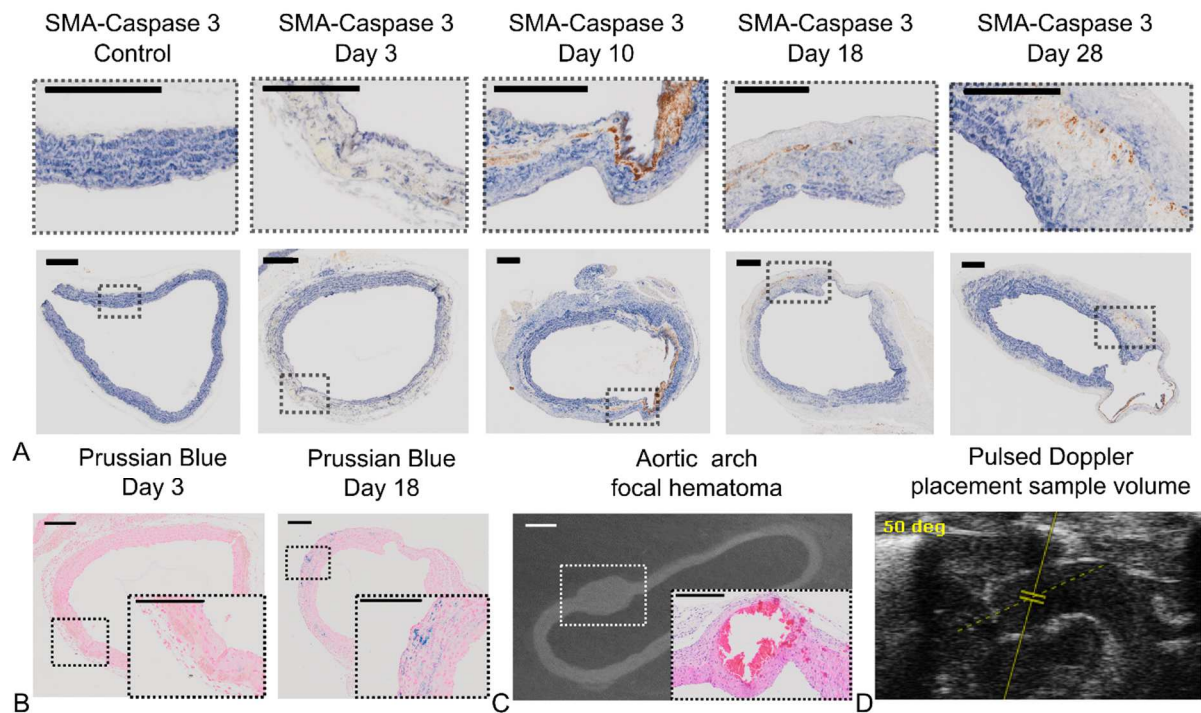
Smooth muscle cells apoptosis, hematoma resorption, focal hematoma formation and Pulsed Doppler sample volume placement. a.
